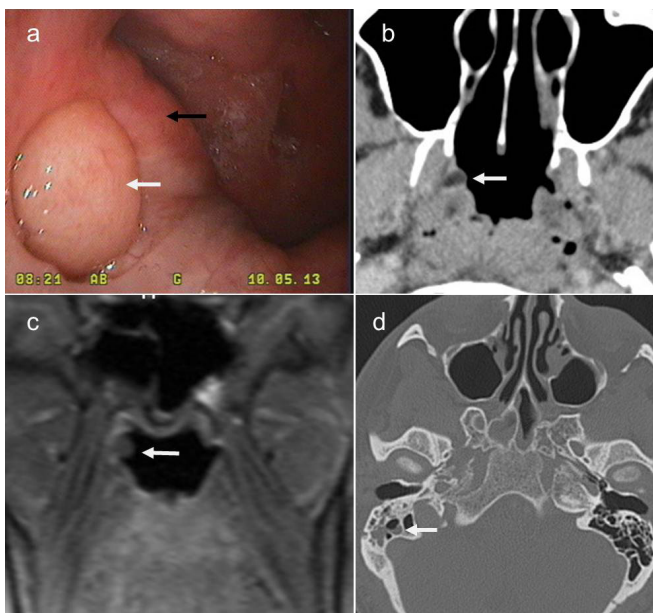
a. Transnasal endoscopic close-up view of the mass that obstructs the pharyngeal orifice of the right eustachian tube (white arrow: fibrolipoma, black arrow: torus tubarius) b. Axial slice of neck CT shows hipodense, well-defined, non-enhancing mass lesion consistent with lipoma(white arrow) c. Coronal view of MRI revealed that the mass lesion limited the mucosa(white arrow) d. Axial image of temporal bone CT displayed the opacification of the right mastoid air cells due to effusion of fluid(white arrow).
